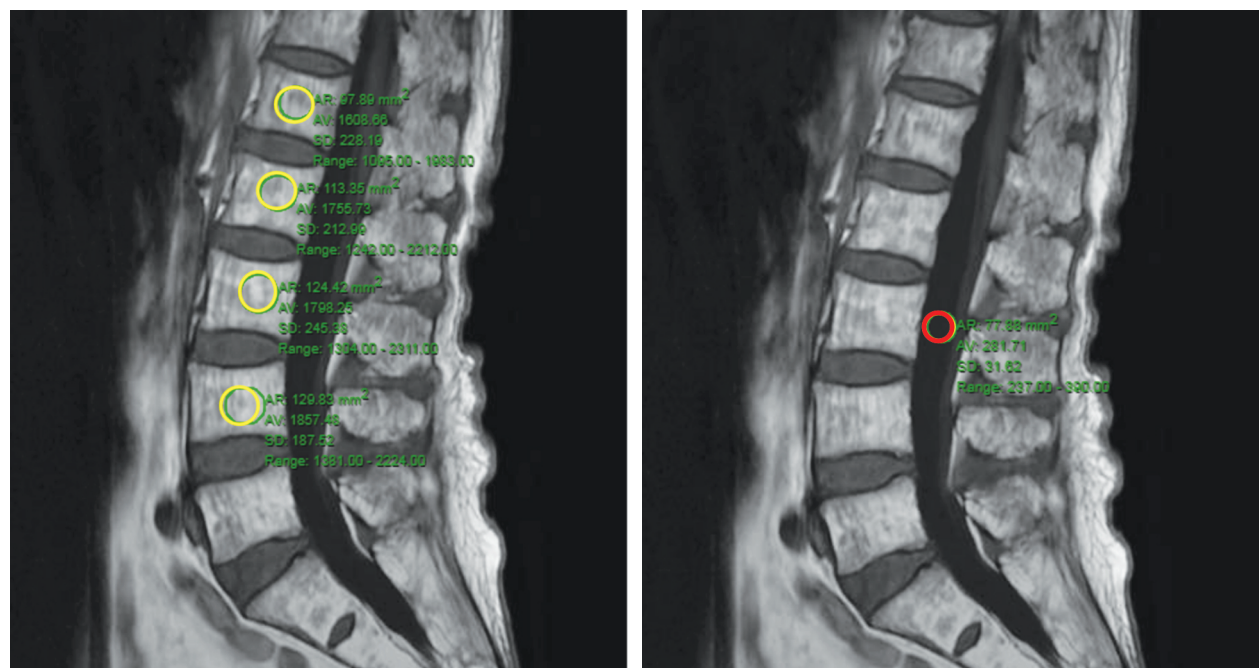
Magnetic resonance imaging (MRI) of lumbosacral spine T1-weight images, Mid-sagittal view, A circular region of interest (ROI) was placed on the L1-L4 mid vertebral body and and L3 CSF SI to evaluate VBQ score.
